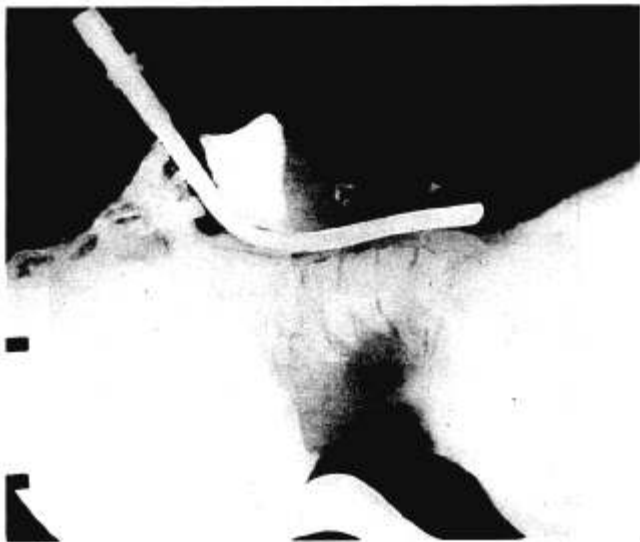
Roentgenogram of oral Woodbridge tube in place. The tip can be seen against the anterior tracheal wall.
